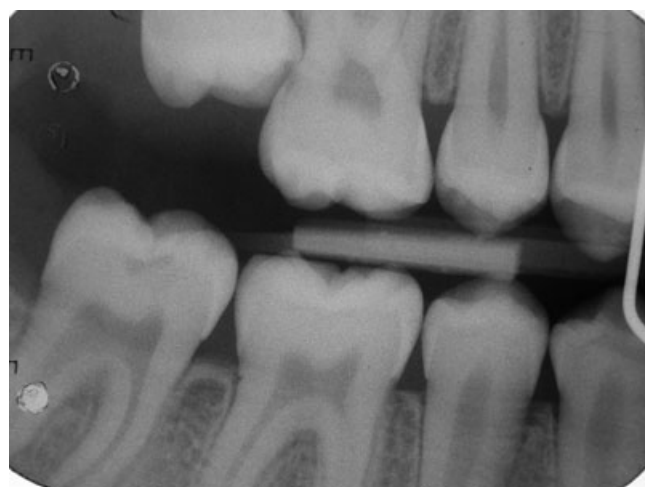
Radiograph showing bitewing 2.
